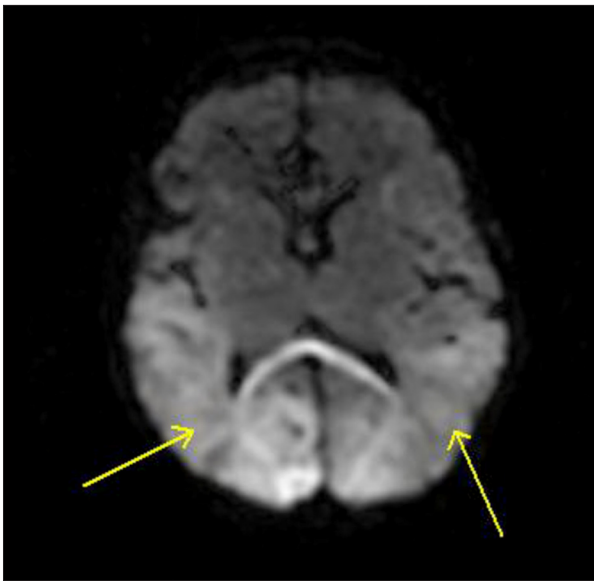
MRI brain diffusion-weighted sequences “demonstrate restricted diffusion in the posterior parietal lobes and occipital lobes bilaterally. There may be restricted diffusion in the left cerebellar hemisphere. Findings consistent with infarcts” per pediatric radiologist. Image reviewed by a pediatric neurologist who agreed with the findings.
